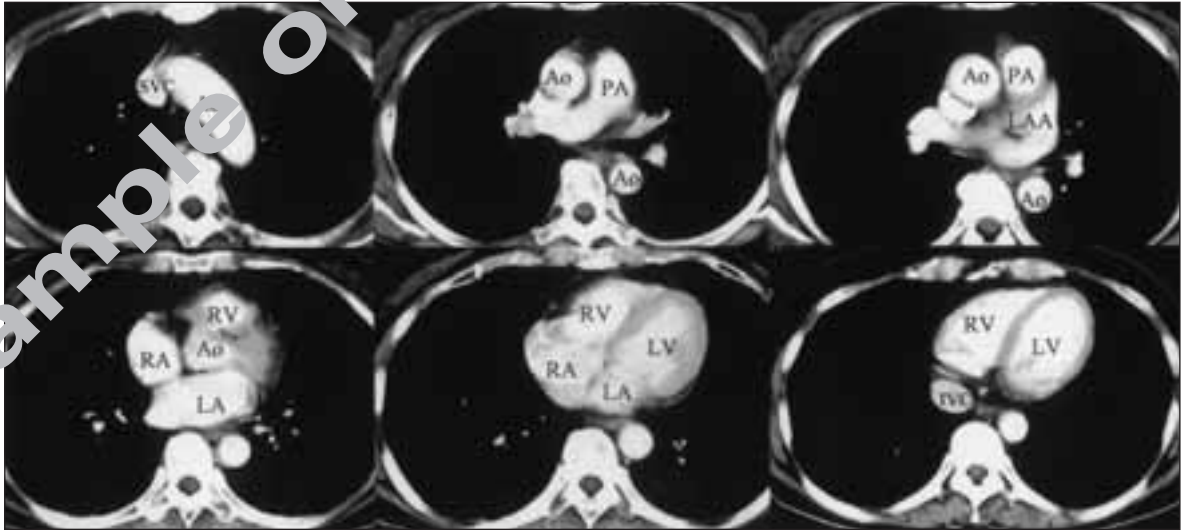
Normal axial CT scans of the heart. (Key: SVC: superior vena cava, IVC: inferior vena cava, RA: right atrium, RV: right ventricle, PA: pulmonary artery, LA: left atrium, LAA: left atrial appendage, LV: left ventricle, Ao: aorta).
